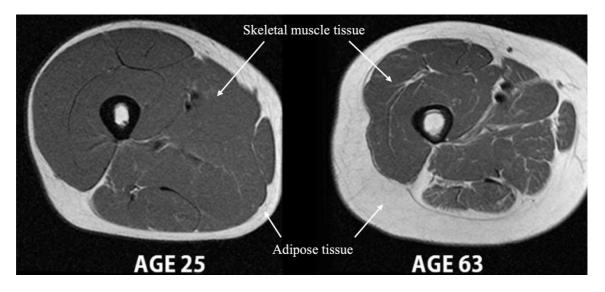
MRI images comparing m. quadriceps in two people (young and older adult) indicating reduced skeletal muscle mass and increased fat mass with ageing.
